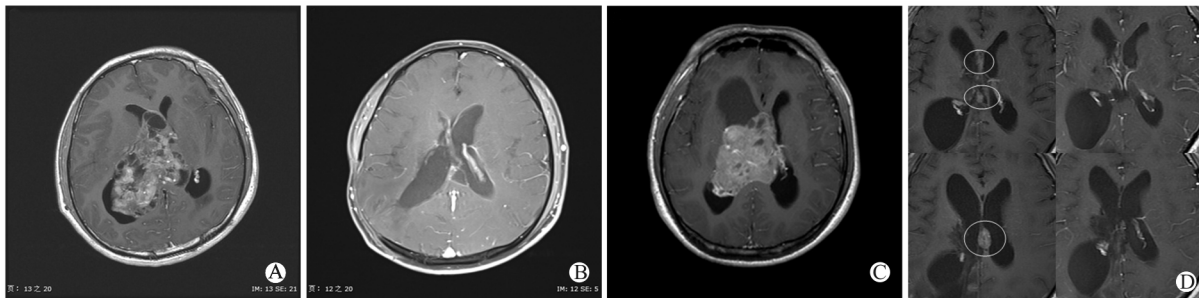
Contrast-enhanced MR images of huge CNs
